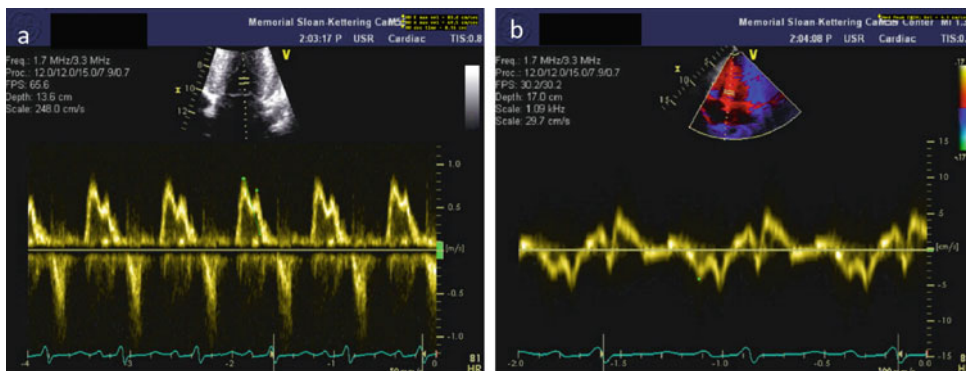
a Pulsed wave Doppler of the mitral inflow: mitral E/A ratio = 1.2, deceleration time 160 ms. b Tissue Doppler of the mitral annulus 4.1 cm/sec. E/E' = 20 consistent with high LV filling pressure
